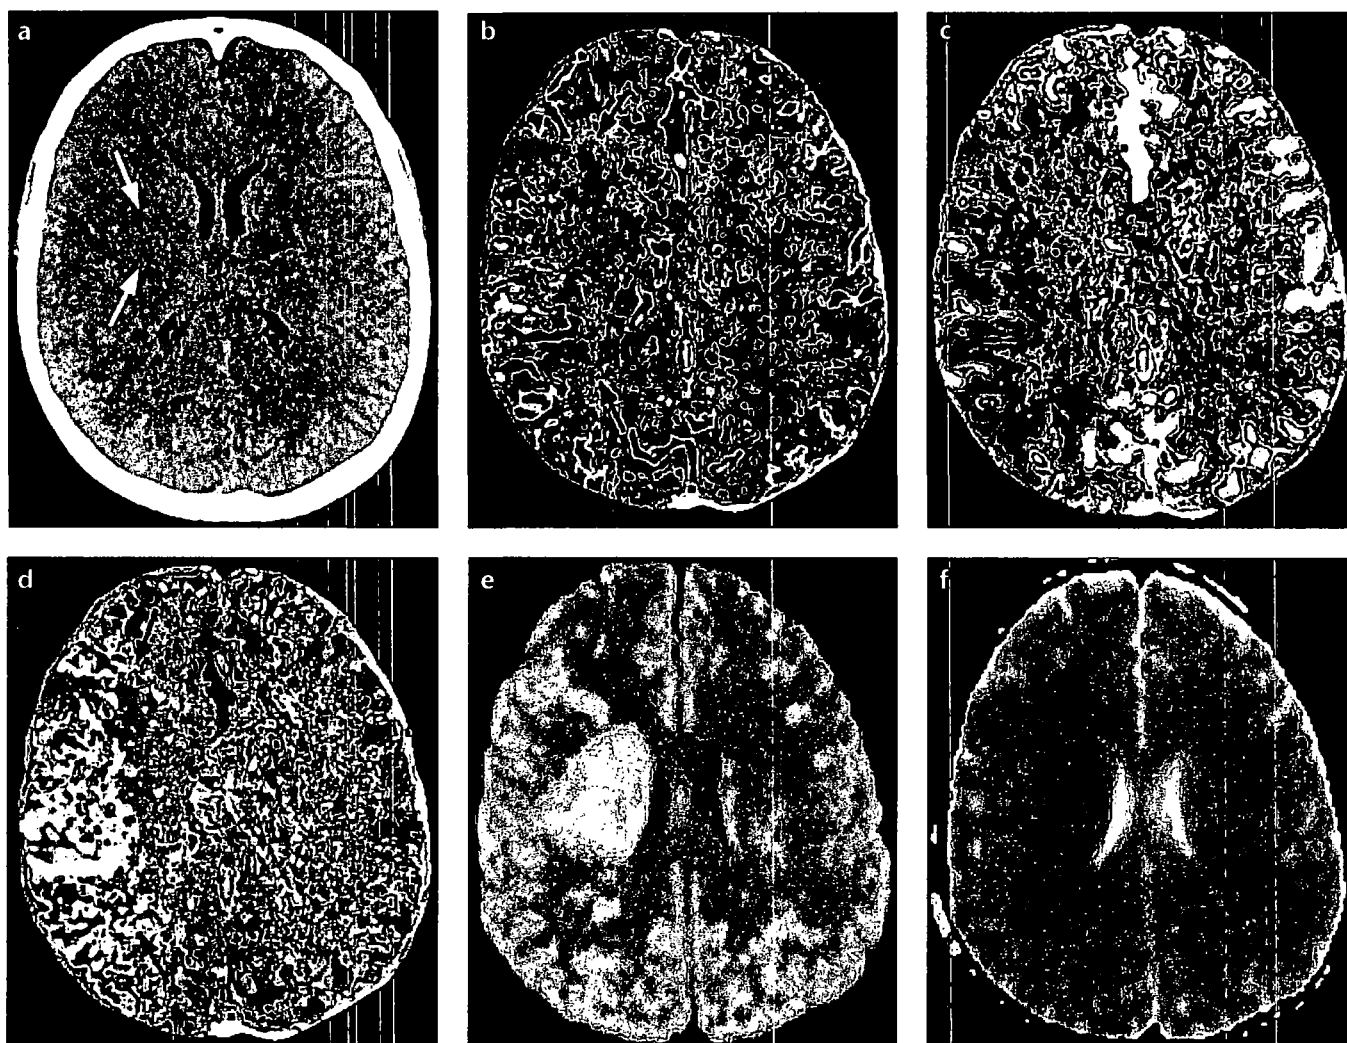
a-e. A 30-year-old female with left hemiparesis. Minimal hypoattenuation is observed on non-contrast axial brain CT image at the level of the right lentiform superior nucleus (a) (arrows) 6 hours after the onset of acute symptoms. Relative cerebral blood volume (b), relative cerebral blood flow (c) and mean transit time (d) CT perfusion maps show large perfusion defect observed in the feeding area of the right middle cerebral artery (arrows). Despite the wide perfusion defect observed on CT images, it was noted that tissue progressing to infarct has been arrested in the right corona radiata on diffusion weighted MR image (e), and apparent diffusion coefficient (ADC) map (f).
